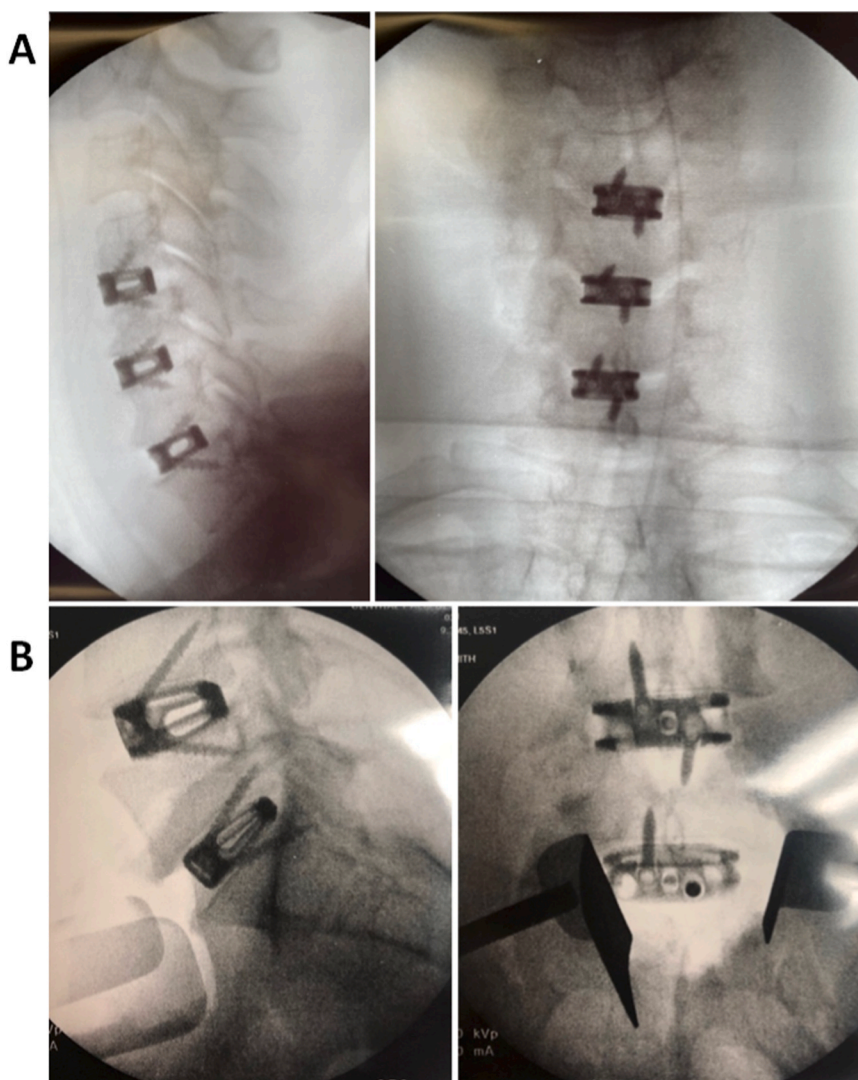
Representative immediate post-operative X-ray images of cervical and lumbar cases. Panel (A) shows lateral (left) view and anteroposterior (AP) view (right) of a 3-level ACDF case at C4–C5, C5–C6 and C6–C7 levels. Panel (B) shows lateral (left) and AP (right) views of a case of 2-level ALIF at L4–L5 and L5–S1 levels.
